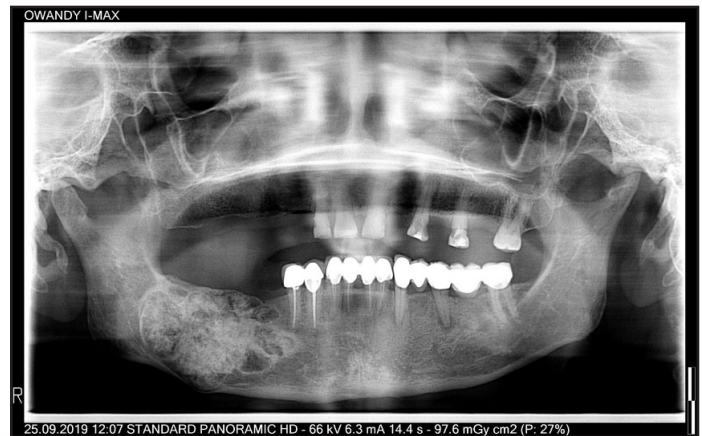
Panoramic radiograph showing large cemento-ossifying fibroma lesion which involve right mandibular premolar- molar region.
